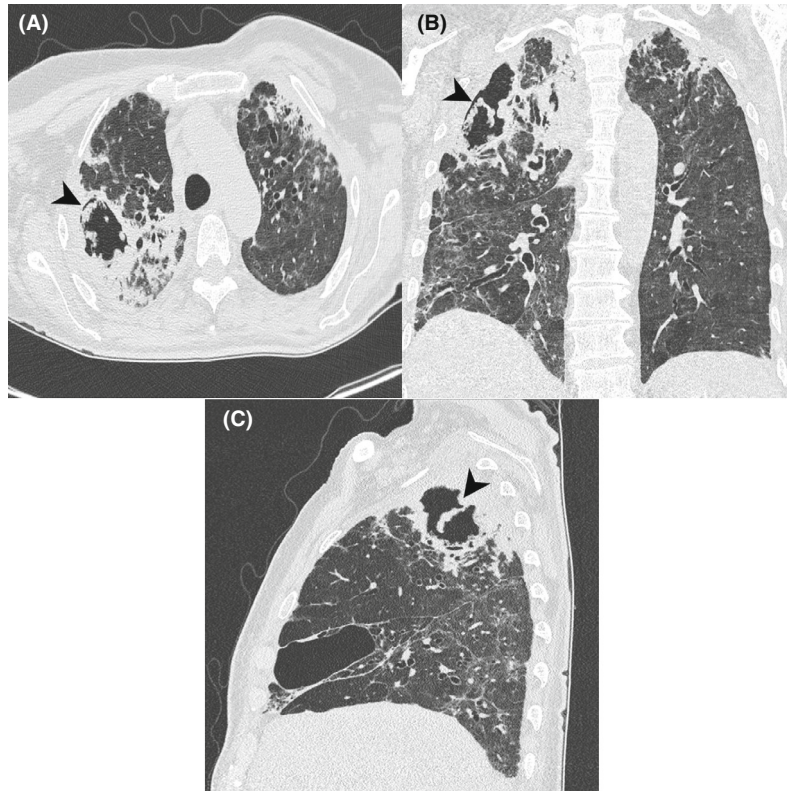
Eleven months after discharge. HRCT: Thick-walled cavities with central fungus ball and air crescent sign (black arrowhead), at positions of previously described pneumoceles combined with tree-in-bud nodules. Aspergilloma or mycobacterial infection is suspected. (A) Axial lung window, (B) coronal lung window and (C) sagittal lung window.
